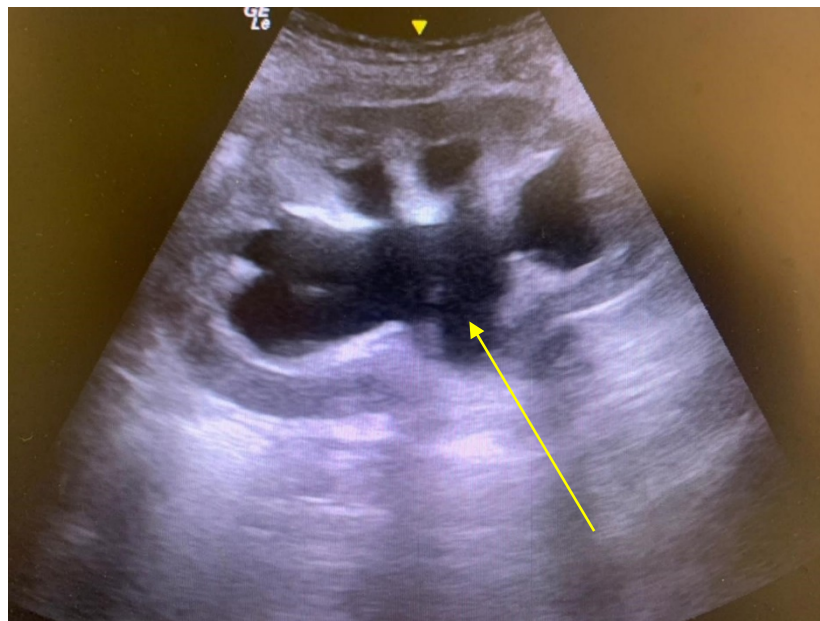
Ultrasonogram of the renal graft 6 months after reconstructive surgery. Pyelocaliceal dilatation (yellow arrow)
